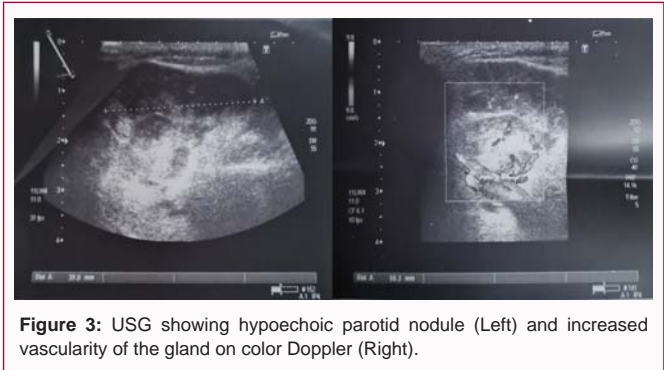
USG showing hypochoic parotid nodule (Left) and increased vascularity of the gland on color Doppler (Right).
